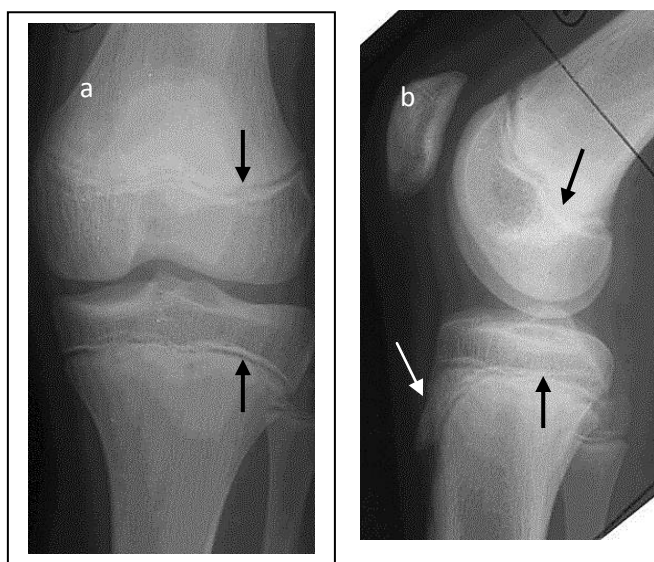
The radiography of a knee joint in direct (a) and lateral (b) projections. The radiography belongs to a child. Zones of metaphysis-epiphysis cartilages in the bones forming a knee joint are detected (arrows) as stripes of radiolucency (epiphyseal plates). An ossification kernel is observed in the area of tuberosity of the tibia (white arrow). Norm
